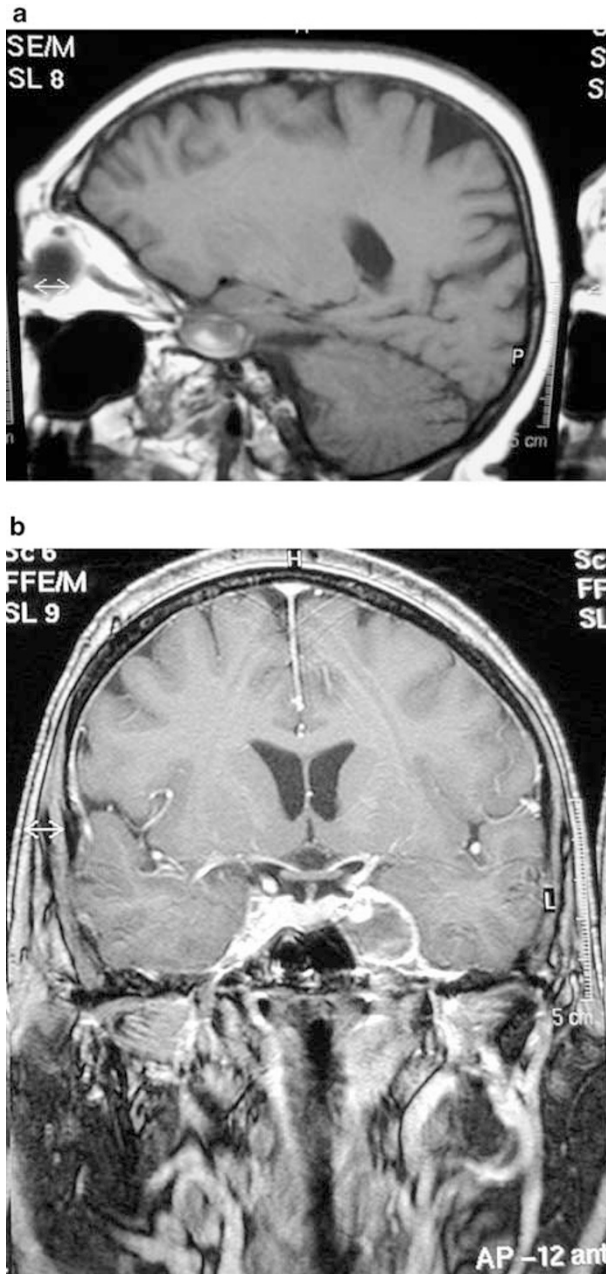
(a) Sagittal T1-weighted MRI scan without gadolinium, demonstrating a small hyperintense area within the thrombus because of recent haemorrhage. (b) Coronal T1-weighted MRI scan with gadolinium, showing peripheral enhancement of the aneurysm and small patent lumen within the thrombus.
